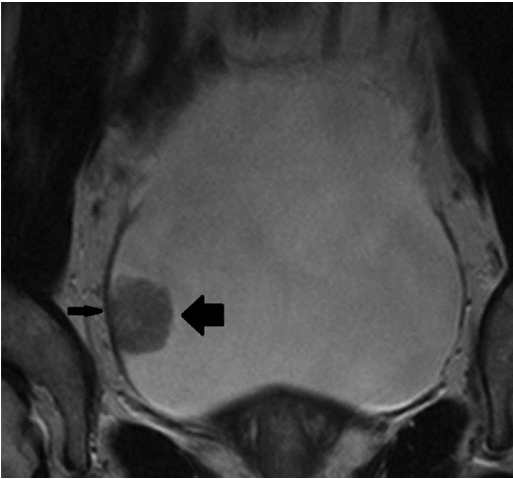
T2-weighted axial image. The *thick arrow* indicates the tumor. The low signal (*thin arrow*) of the detrusor muscle is uninterrupted in keeping with T1 stage.
